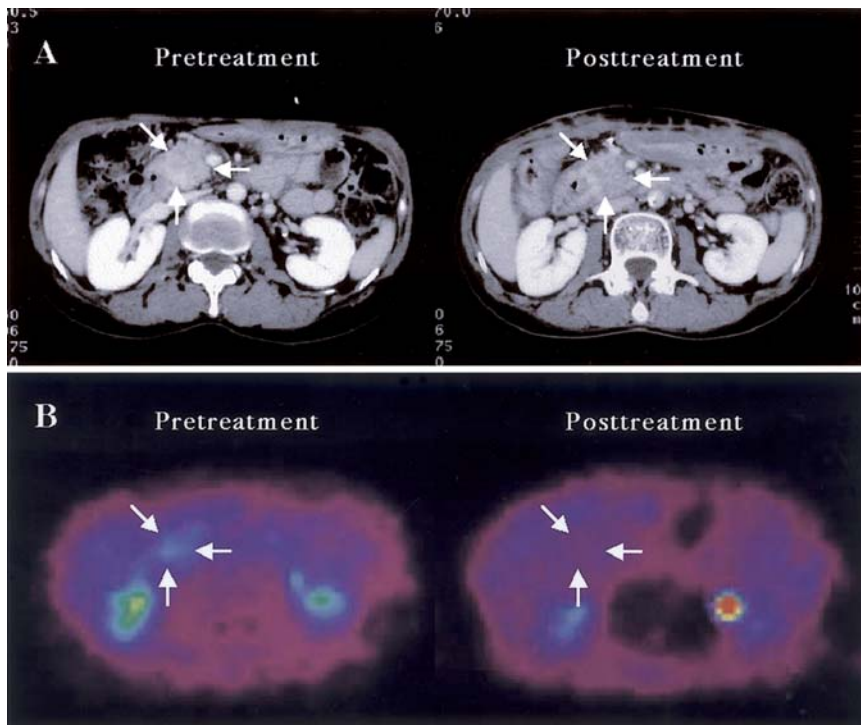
Diagnostic images of patient 9, as a representative of category III. A The size of the tumor in the pancreatic head (*arrows*) is not visibly reduced in the posttreatment stage. B Pretreatment PET image shows increased FDG uptake in the pancreatic head (*arrows*); uptake is clearly reduced in the posttreatment stage
